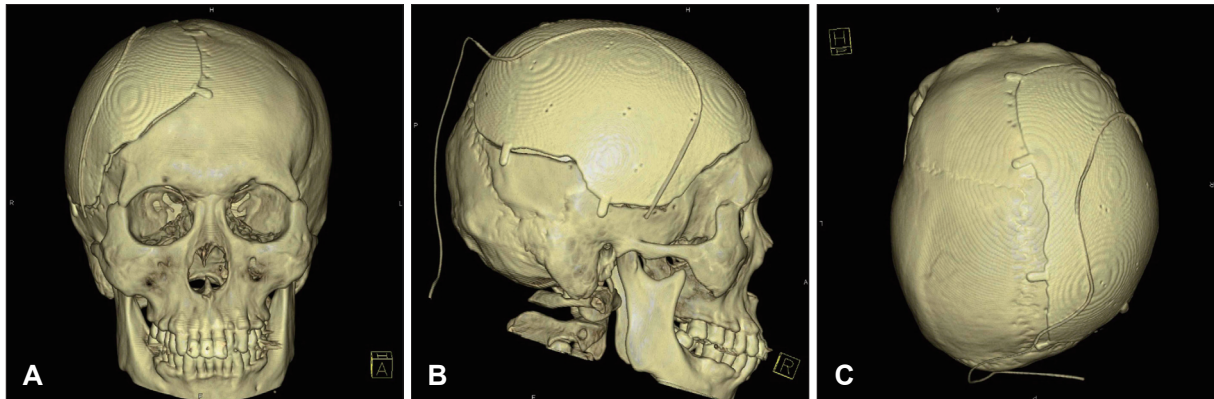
Brain computed tomography (CT) three-dimensional (3D) reconstructions after cranioplasty with Titanium skull flap. Bone flap is made by 3D printing with electron beam melting technique. Pre-craniectomy brain CT and pre-cranioplasty CT were used for tailored flap. Subgaleal drain catheter is seen above metal flap. (A) Frontal view, (B) Right lateral view, and (C) Apical view.
